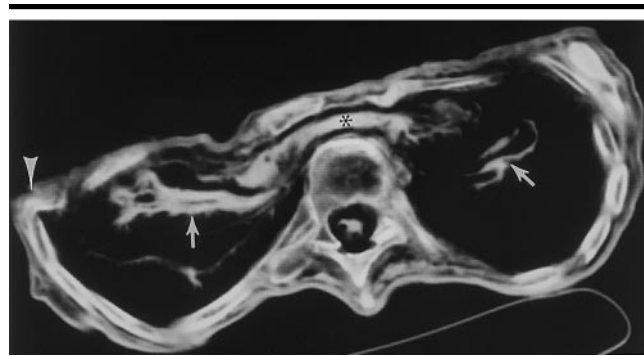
Transverse CT section through the thorax (obtained on May 3, 1994) confirms the compressed anteroposterior diameter of the thorax and displays the right-angle deformity (arrowhead) of the rib cage that was acquired as the corpse adjusted to the changing forces brought about by progressive dehydration and increasing pressure from the weight of snow and ice. The wafer-thin heart (*) is sandwiched between the juxtaposed sternum and spine. The dehydrated lungs (arrows) are only wisps of tissue.
